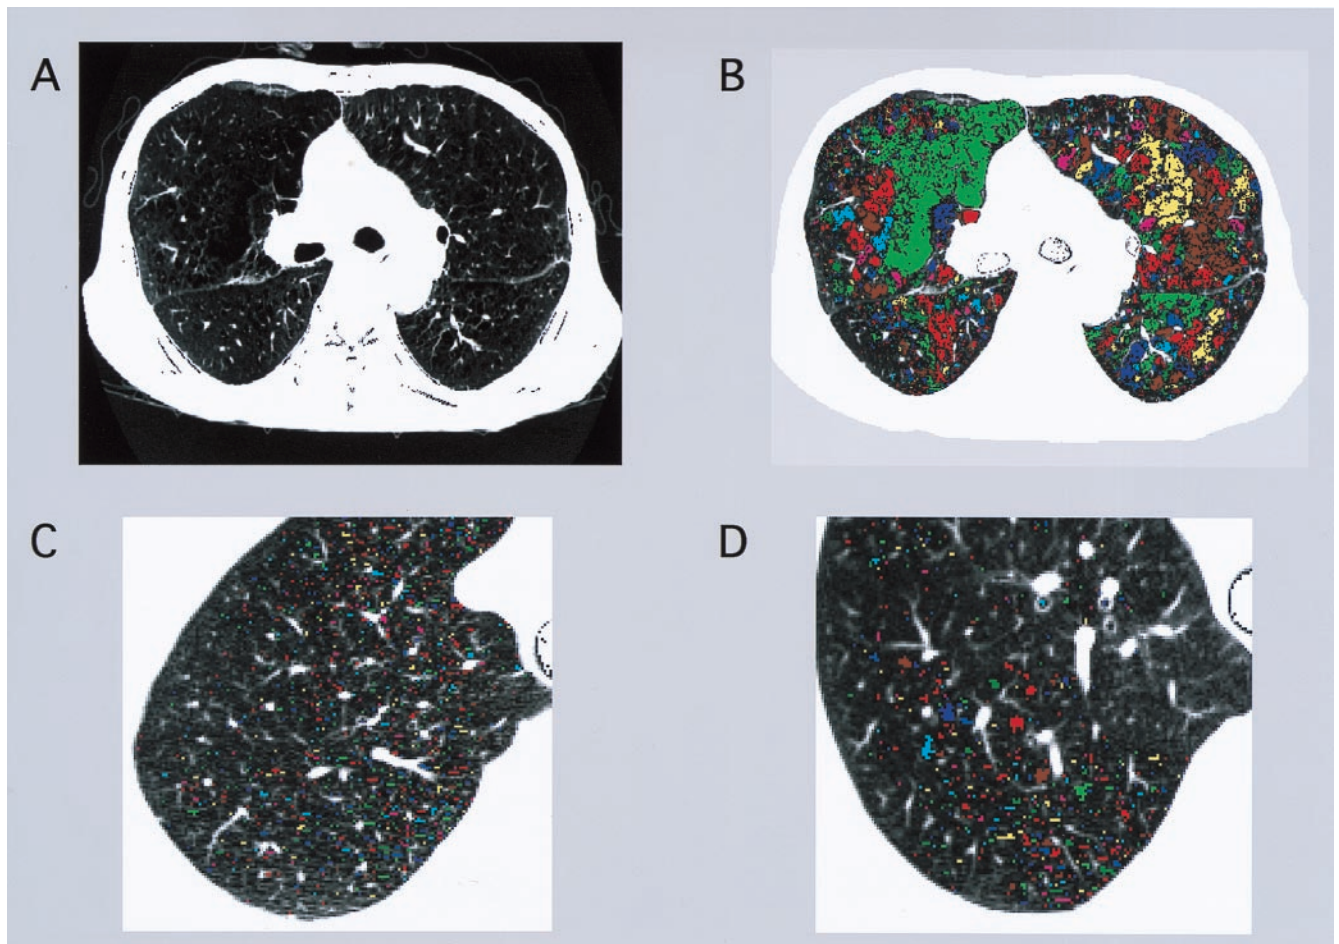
(*A*) Original CT image of the middle lung slice in a representative COPD patient. LAA% is 55.1. (*B*) The same image as in *A*, but the individual clusters comprising contiguous LAA regions are shown in contrasting colors. The lung field was identified from the rest of the image, and the lumen of the trachea and large bronchi were excluded. The white regions are smaller airways and vessels. (*C*) LAA image of a normal subject. (*D*) LAA image of a COPD patient. The LAA% and exponent *D* of the cluster distribution of the two images in *C* and *D* are 7.2 vs. 7.1 and 2.97 vs. 1.71, respectively.
